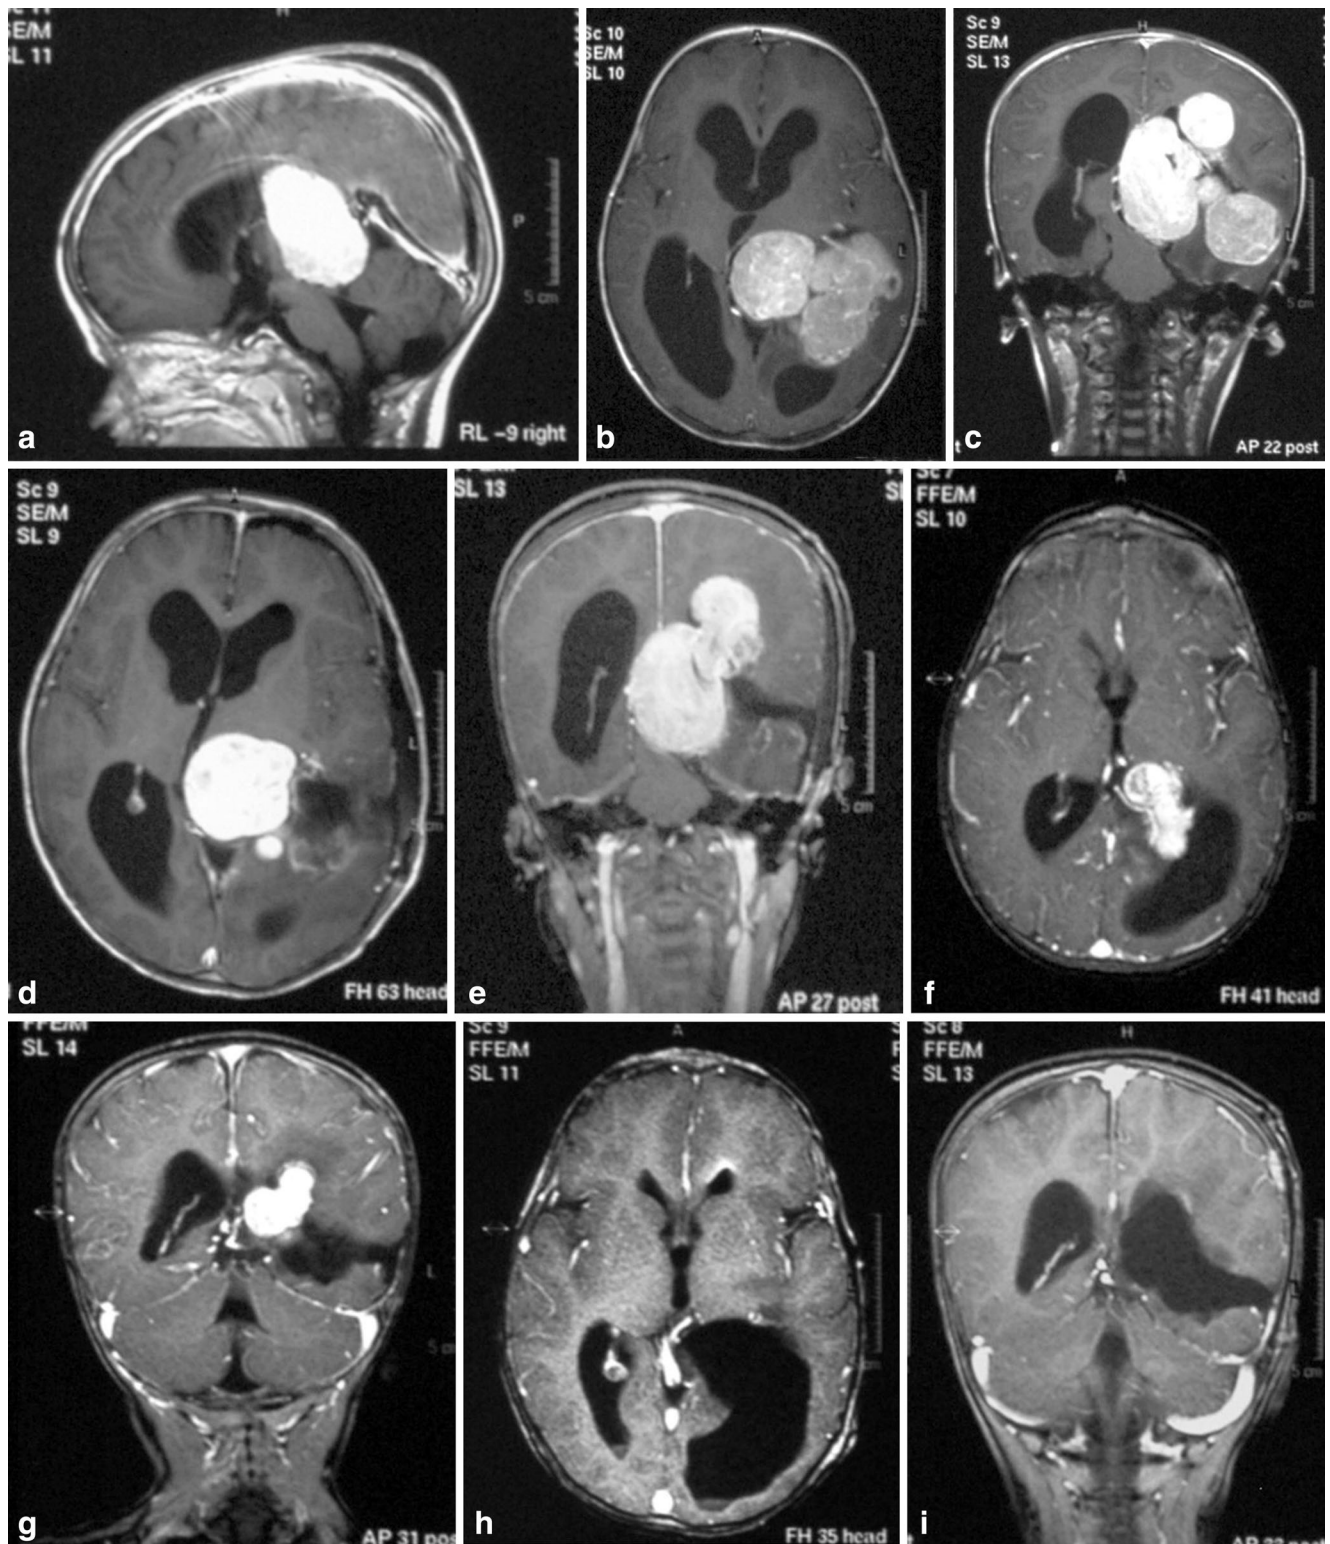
Huge left lateral ventricle choroid plexus carcinoma (Case 5). Sagittal (a), coronal (b), and axial (c) contrast-enhanced T1 weighted MR images at presentation. Note hydrocephalus secondary to aqueductal stenosis on midsagittal image (a). Coronal (d) and axial (e)
